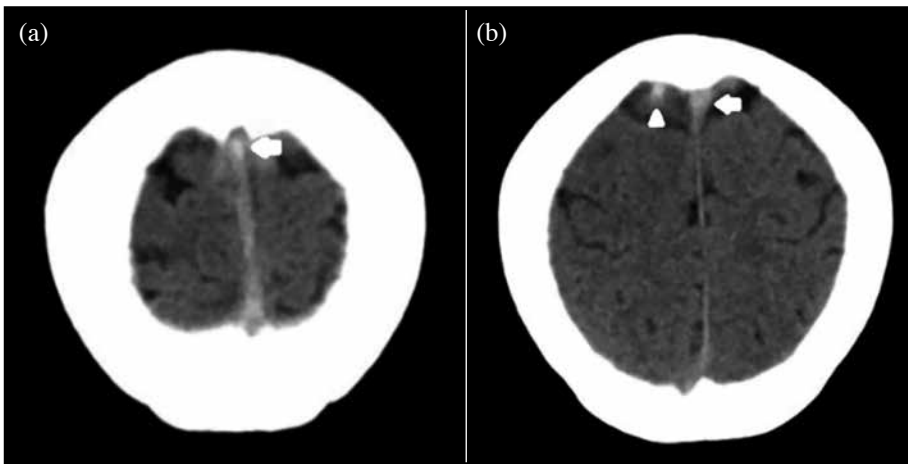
Non-contrast computed tomography of the brain showing hyperdensities at the superior sagittal sinus (arrows) and the cortical vein (arrowhead) suspicious of cerebral venous sinus thrombosis.
